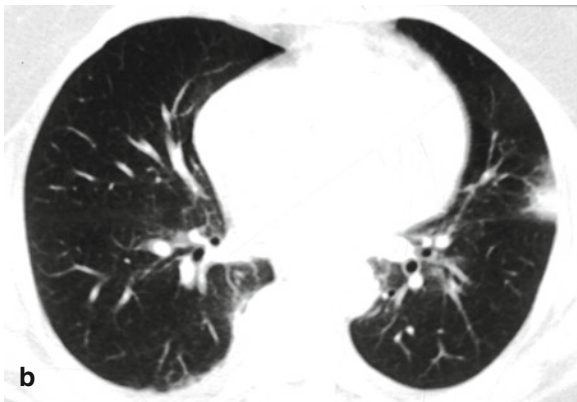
(a) Older pulmonary infarction. Even in the absence of a pleural effusion the protruding surface of the pleural infarction is clearly seen (arrow). (b) This infarction was seen on sonography 4 days earlier than on the fluoroscopic chest X-ray
